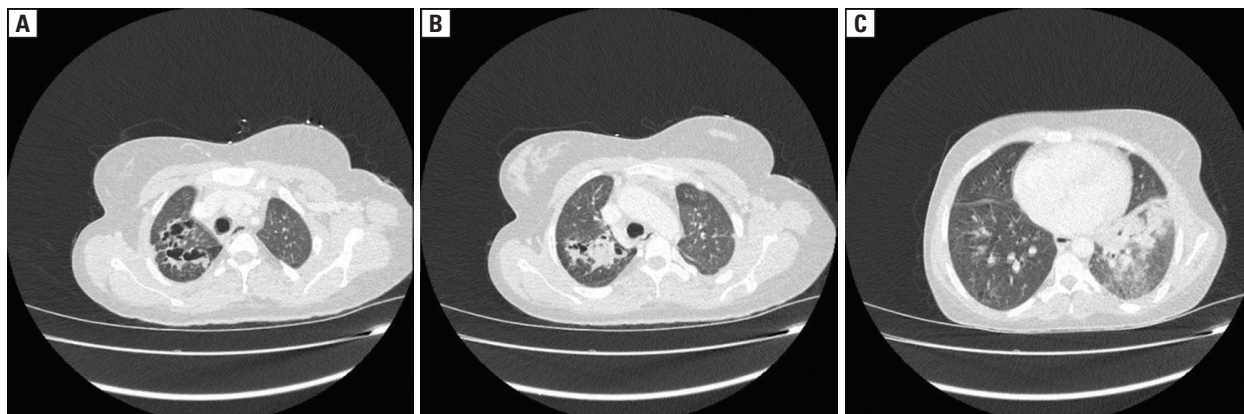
Chest computed tomography showed cystic bronchiectasis in the right upper lobe (A), a fluid-filled cavity in the middle lobe (B) and consolidation in the left lower lobe (C)
